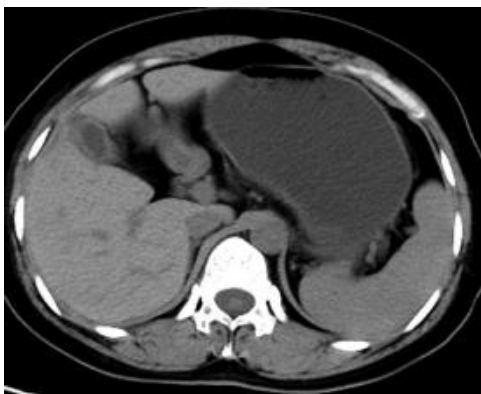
Computed tomography scan of the gallbladder three months after the procedure. The gallbladder was free of stones
